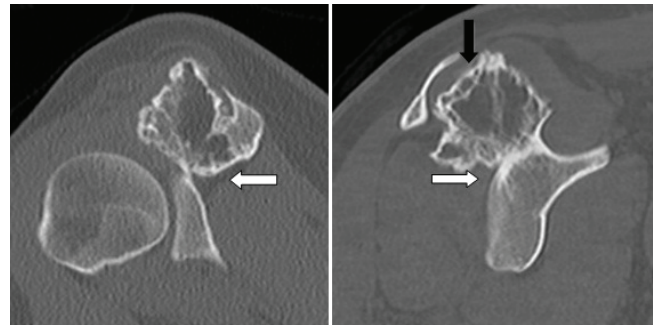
Coronal and sagittal CT images showing osteochondroma arising from glenoid (white arrow) and protruding into the subacromial space (black arrow).
